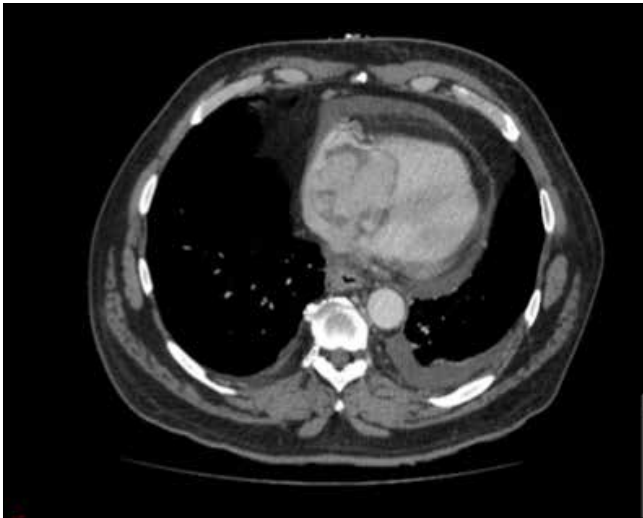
CT scan with white arrow pointing at tumour tissue in right atrium
